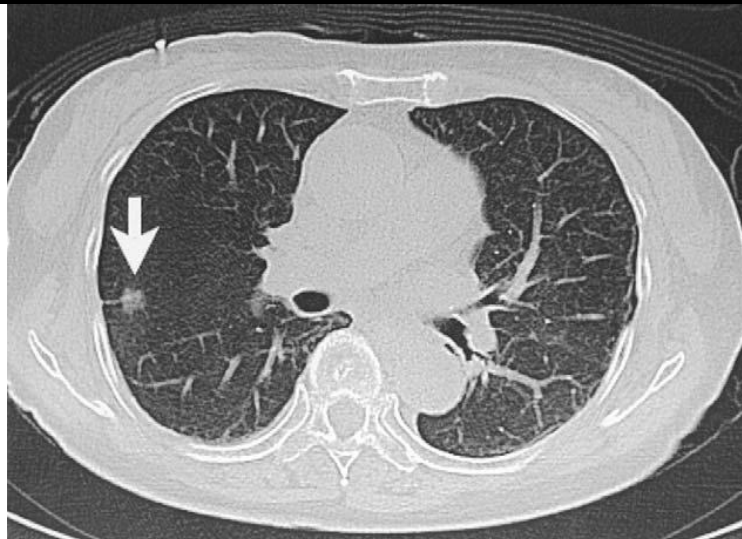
a nodule in the right lung of a 75-year-old woman with suspected coronary artery disease who underwent a 64-slice multidetector computed tomography scan. The nodule was pathologically proved to be adenocarcinoma.
